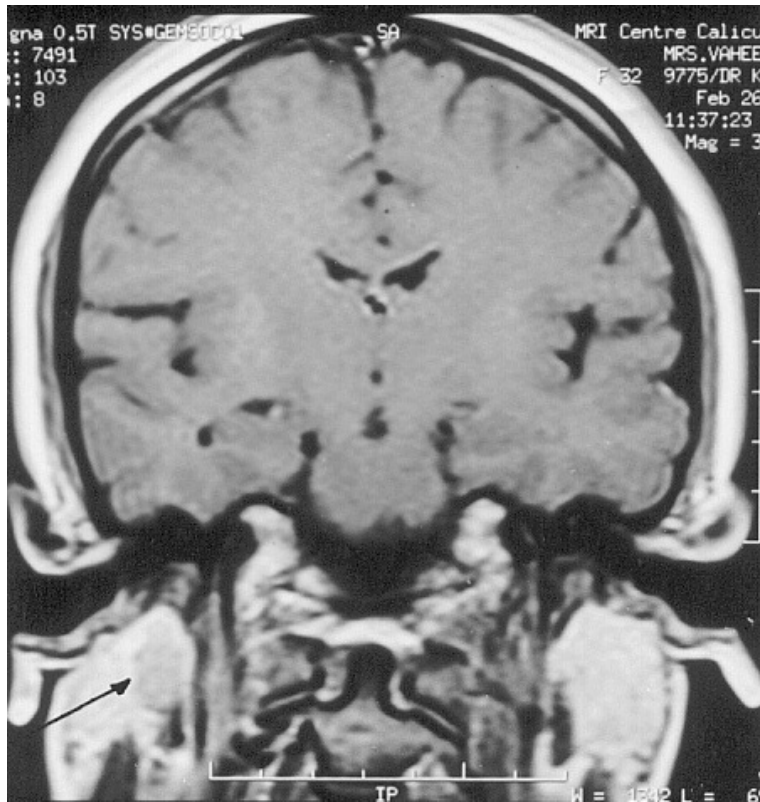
Coronal MRI scan of parotid tumour
